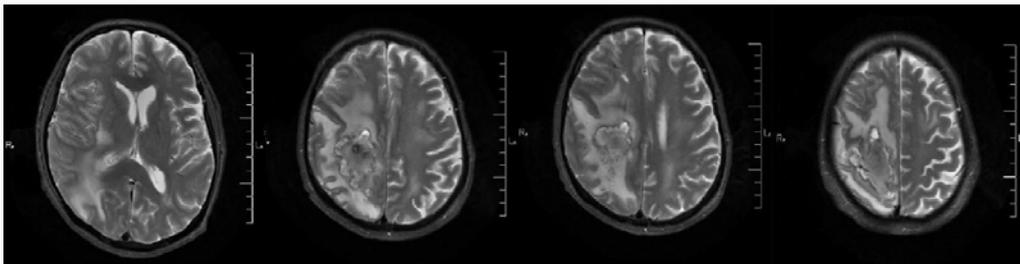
MRI head, T2 sequence, demonstrating bilateral posterior leukoencephalopathy.
